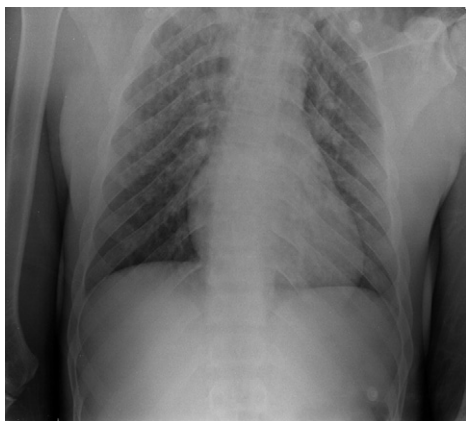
Portable chest radiograph.
